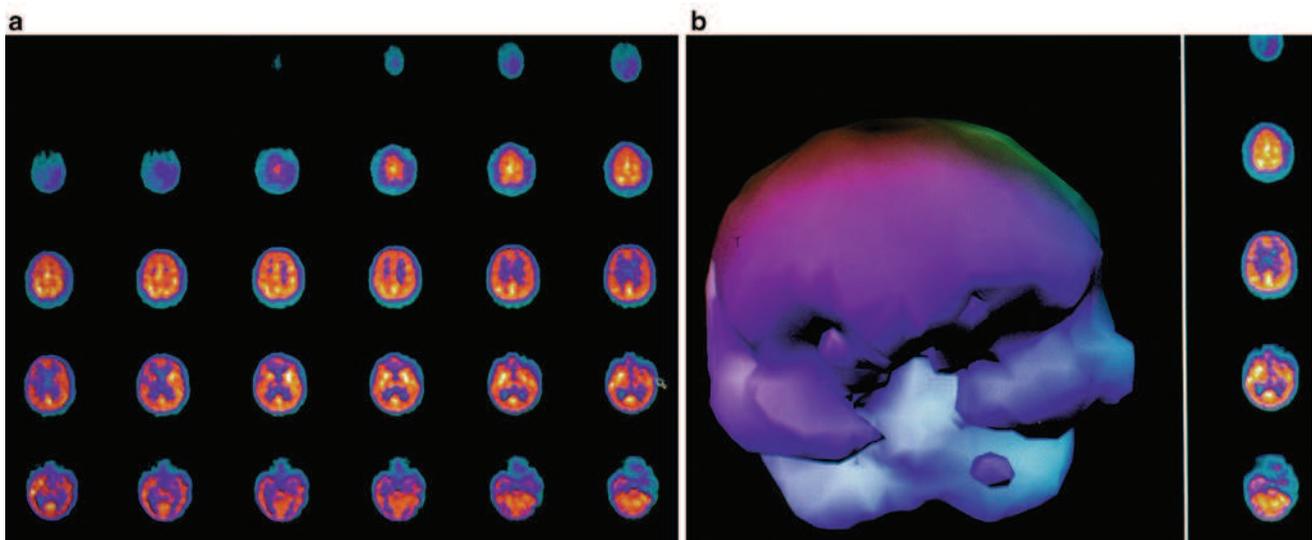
(a) HMPAO SPECT brain imaging, transverse slices, 9 days after Fig. 20.1a, b and 2 h post 5th additional hyperbaric treatment. Note improvement in flow to the left frontal, parietal, and temporal
